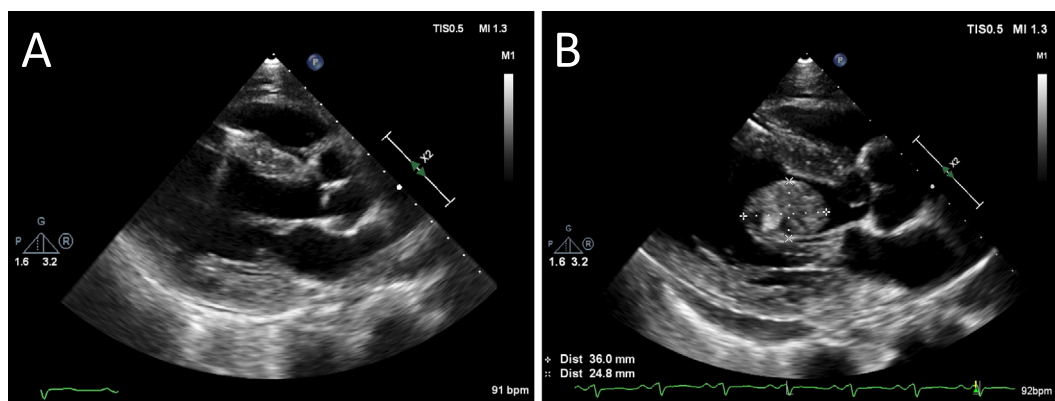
Parasternal long-axis image obtained during the diagnosis of adult T-cell leukemia/lymphoma. B: Parasternal long-axis view obtained at the onset of cardiac symptoms.
